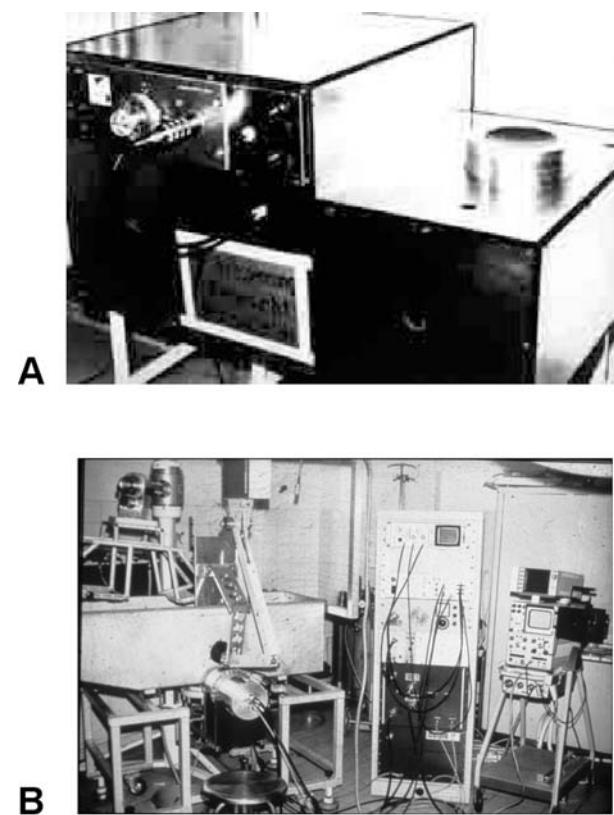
Early lithotripters. (A) TM1 for *in-vitro* and *in-vivo* experiments. (B) TM2 with integrated ultrasound localization.
